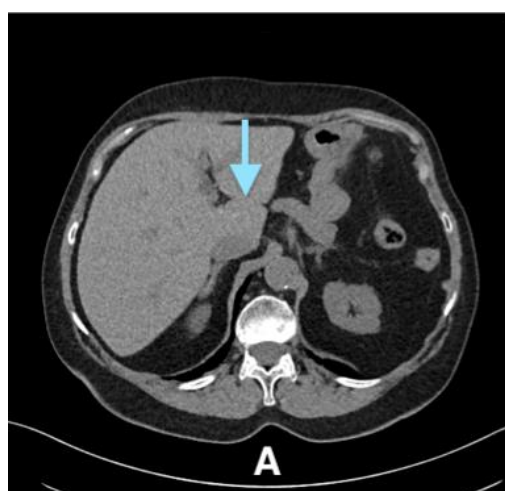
Patient's NECT (A) and PET (B) examinations. No morphological signs of metastasis (blue arrow) on NECT, while significant radiotracer uptake is seen on ^{68}Ga PET/CT.
